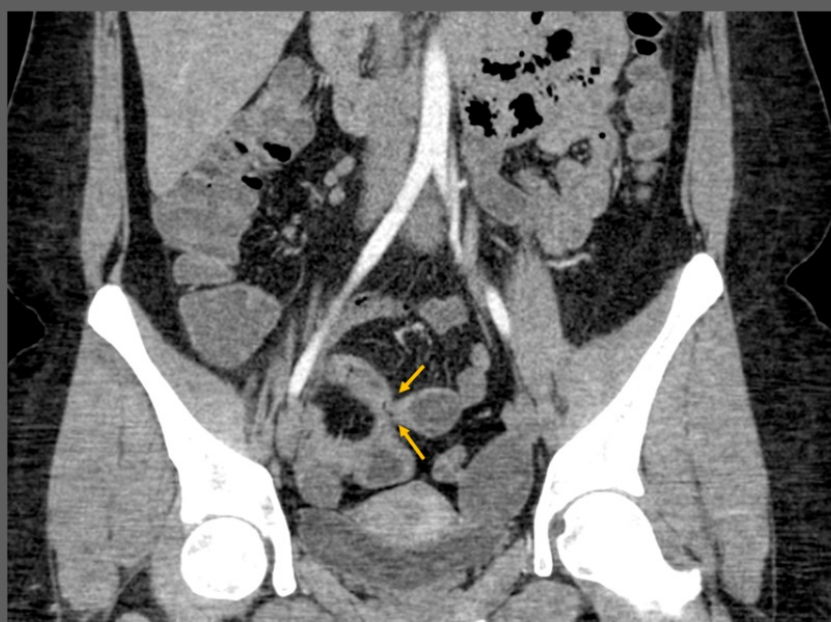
Fistula formation in Crohn disease. Coronal volume-rendered CT enterographic section depict ileo-ileal fistula (arrows).
